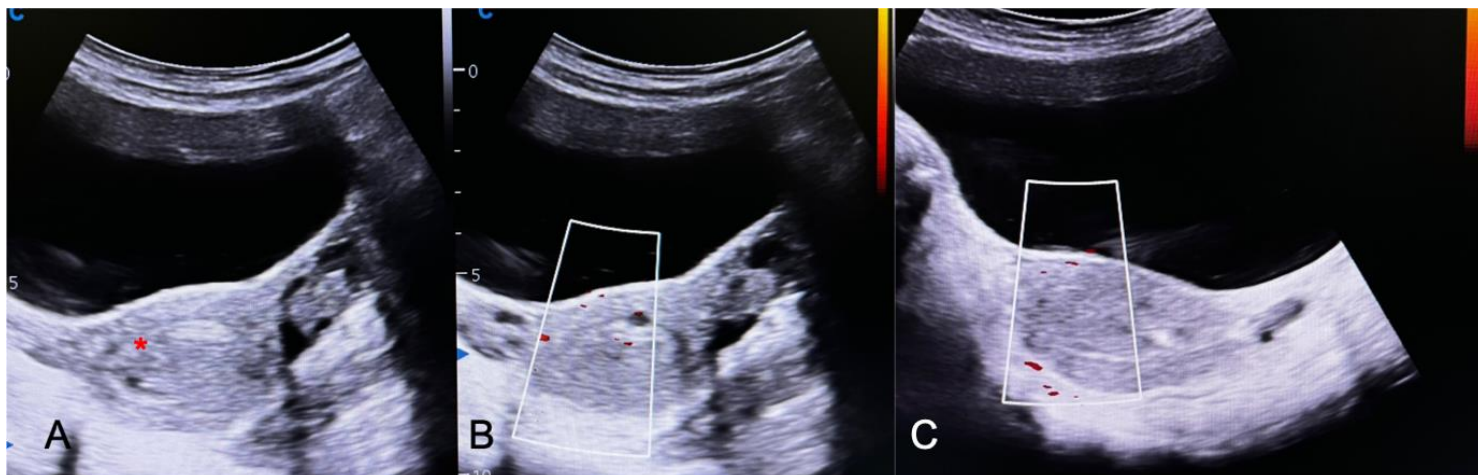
(A-C): Grey scale transverse ultrasound image showing complete thrombosis of the pseudoaneurysm (Red asterisk) (A). Power Doppler images showing no colour flow in the pseudoaneurysm (B, C)
